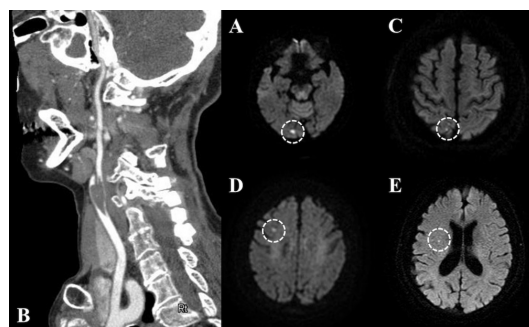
(A) MRI of the head on day 1 showed small hyperintensities in the right occipital lobes. (B) CT angiography of the head and neck revealed a thrombus in the right common carotid artery floating across the carotid bifurcation. (C–E) Serial MRI on days 2, 3 and 6 showed an increase in multiple microthrombuses.
